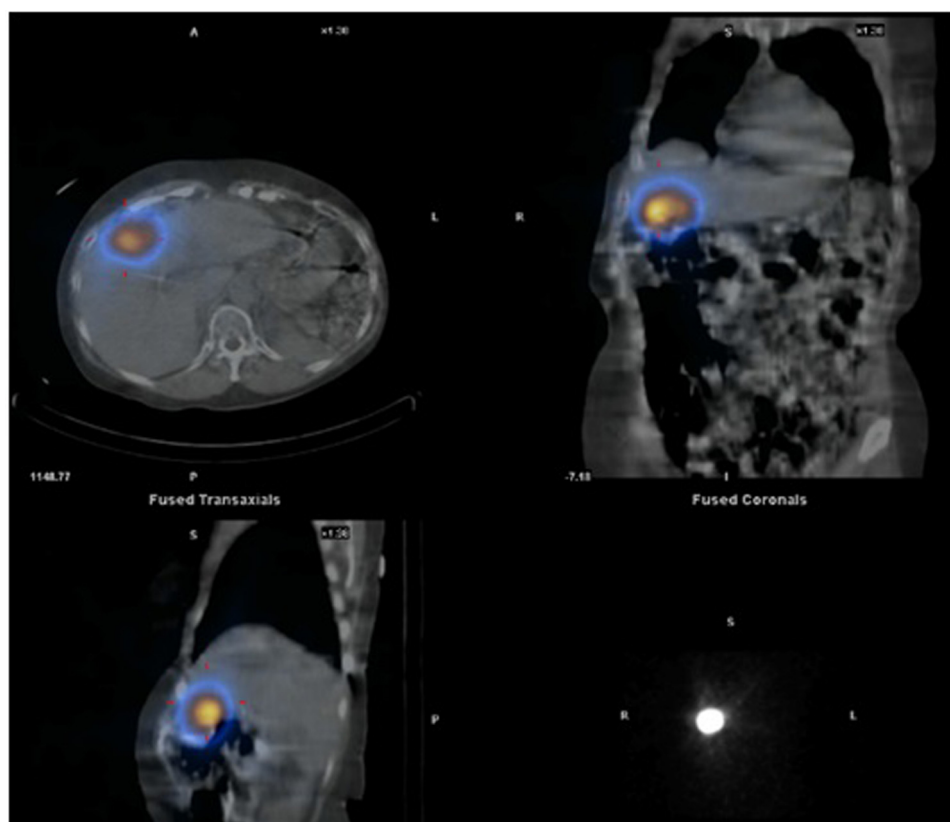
Positron emission tomography (PET) scan demonstrates an isolated focus of FDG uptake in the liver indicating an isolated metastatic focus of tumor.
